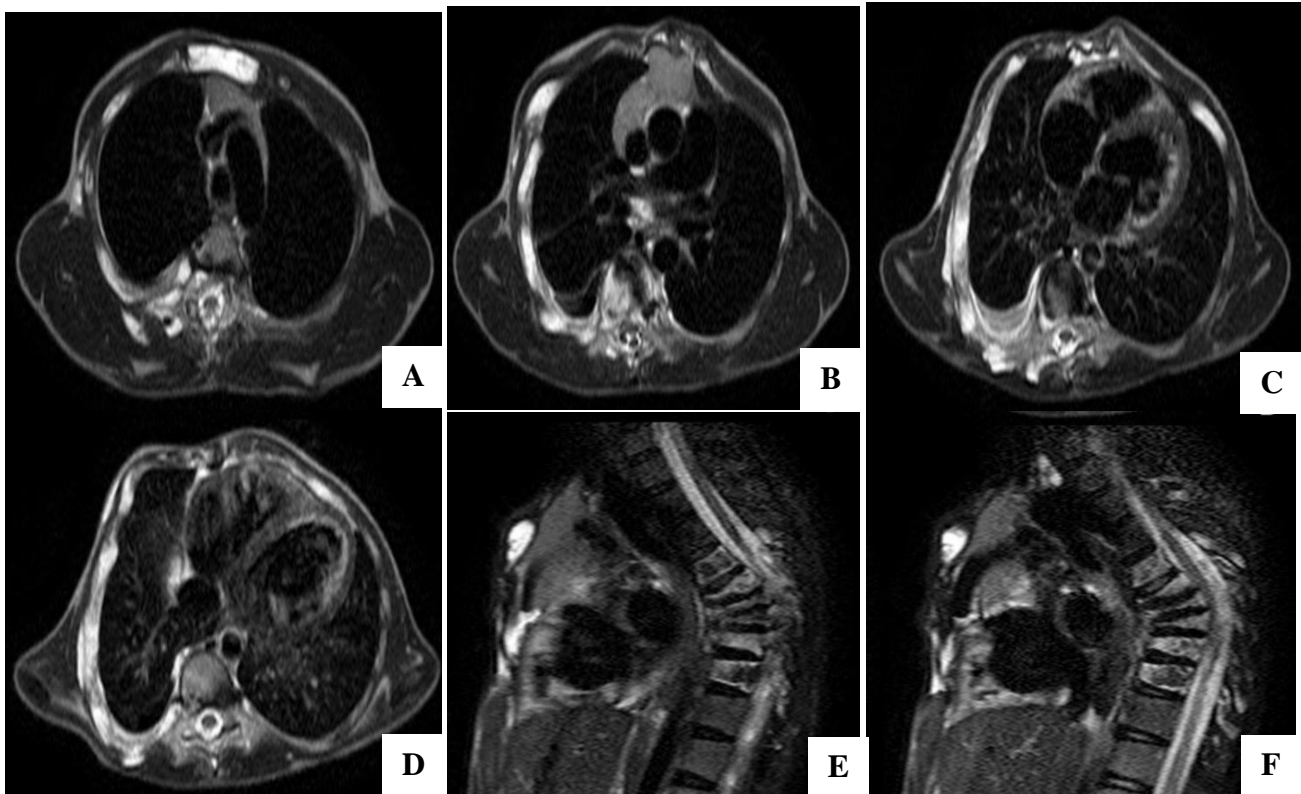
MRI thorax of the patient. T2W axial scans at the level of (A): aortic arch, (B): pulmonary trunk, (C): upper heart, (D): lower heart, and sagittal scans at the level of (E): paramedian region and (F): midline show normal manubrium with complete absence of any bony or cartilaginous component of body and xiphoid process of the sternum with kyphosis. Rest of the visualized soft tissues and spinal cord appear normal.
